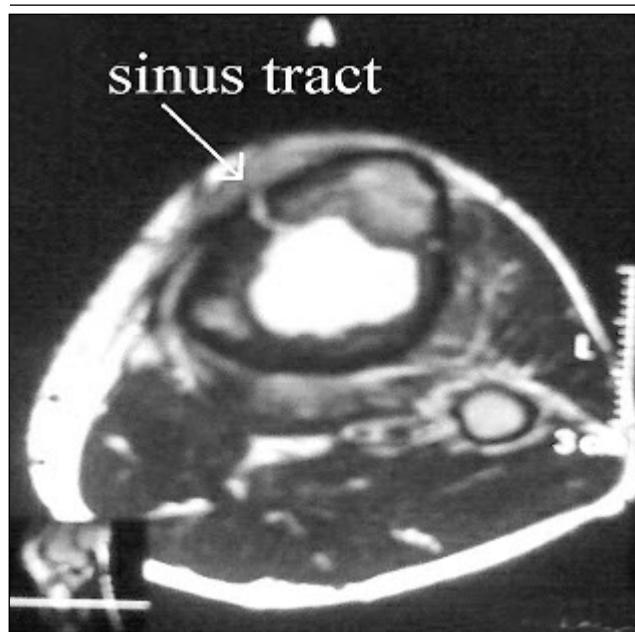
MRI of left upper tibia shows localized area of signal abnormality along with sinus tract at the medial end of left tibia
